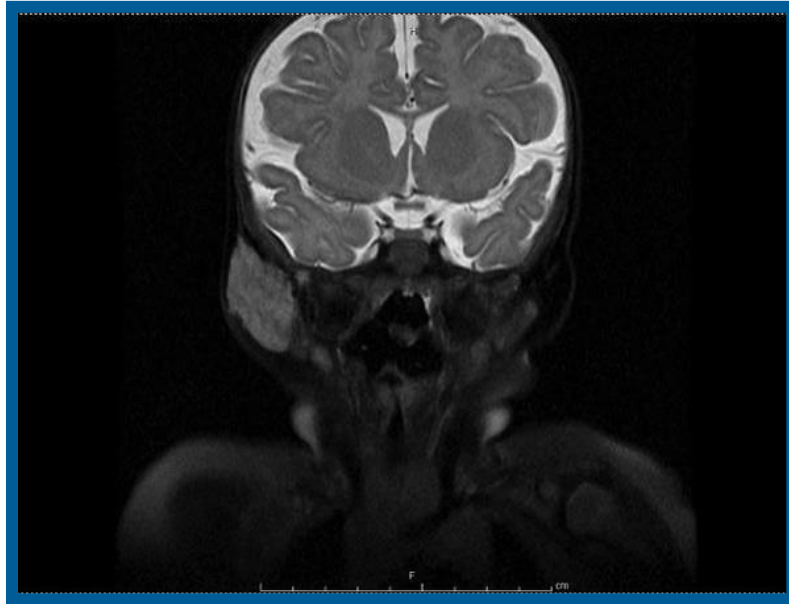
MRI of the parotid - coronal section (T2 with fat suppression), demonstrating focal hemangioma of the right parotid
